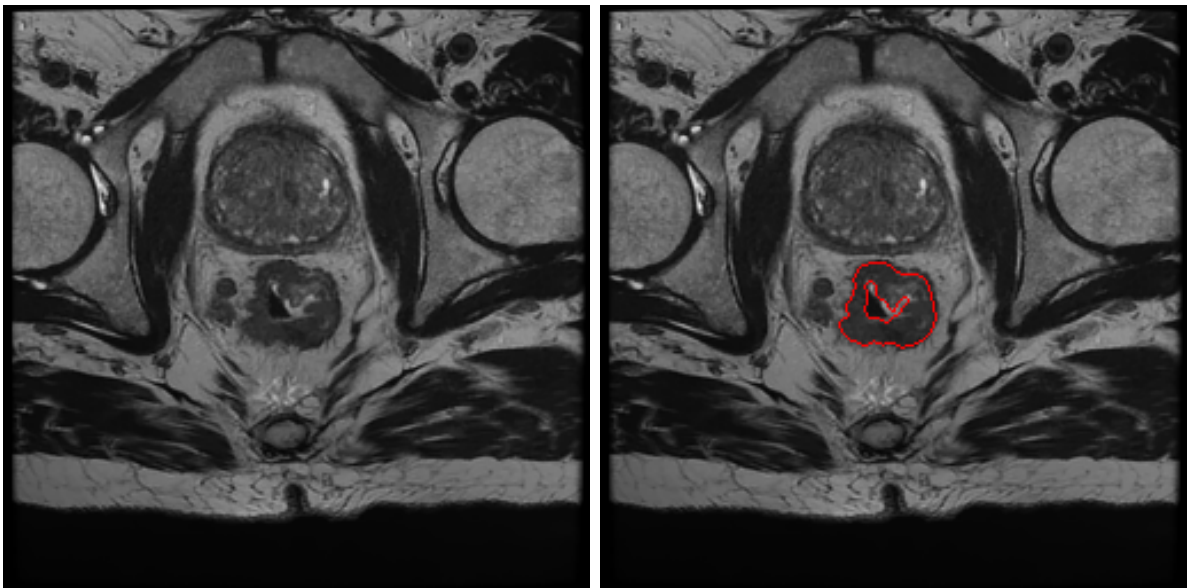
Left)* Original MRI scan. *Right)* Segmented colorectal cancer region.
